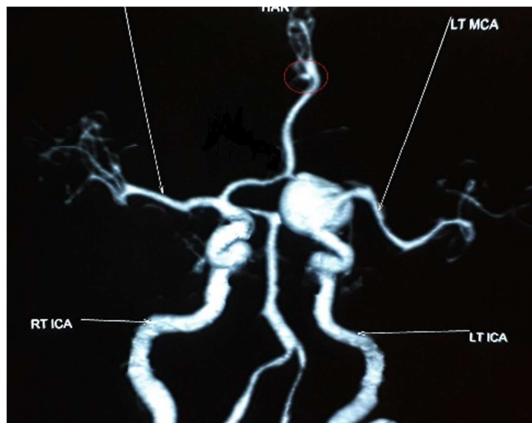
3D reconstruction of CT angiography depicting the giant aneurysm in left ICA and distal ACA aneurysm (red circle).
